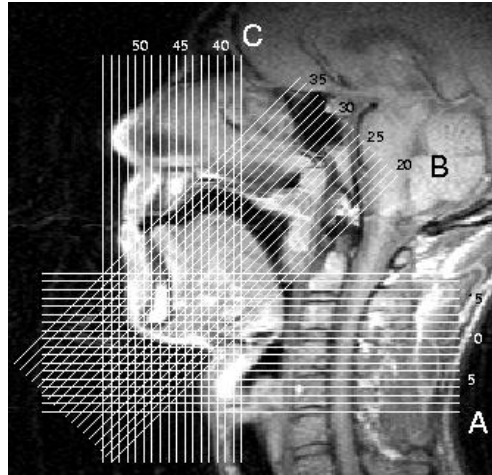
Three-dimensional reconstruction of the HUA using MRI slices. The white lines indicate image slices. Three sets of image slice series can be seen (A, B and C) [32].
